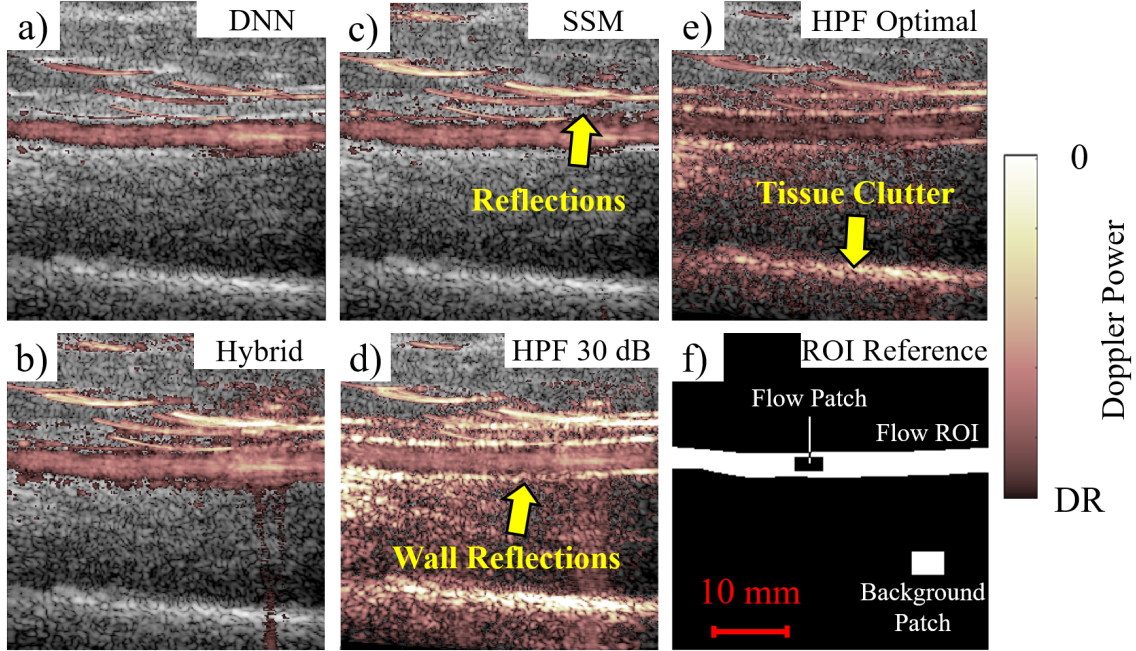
Power Doppler images produced using clutter filtering techniques (Table 5) during systole where significant patient motion is present in the brachial artery (Frame 100 of D5B). Power Doppler images were obtained using *a)* The proposed DNN SVD clutter filter, *b)* hybrid method, *c)* SMM correlation method, and *d)* and *e)* high-pass FIR filter. Panes *a)* - *c)* are presented under 20 dB dynamic range. Pane *d)* is presented under 30 dB dynamic range. Pane *e)* has been rescaled to a DR of 56.6 dB DR relative to the maximum pixel intensity. Pane *f)* shows an example segmentation of the total flow region and the flow and background ROIs used to compute the values in Table 8.
